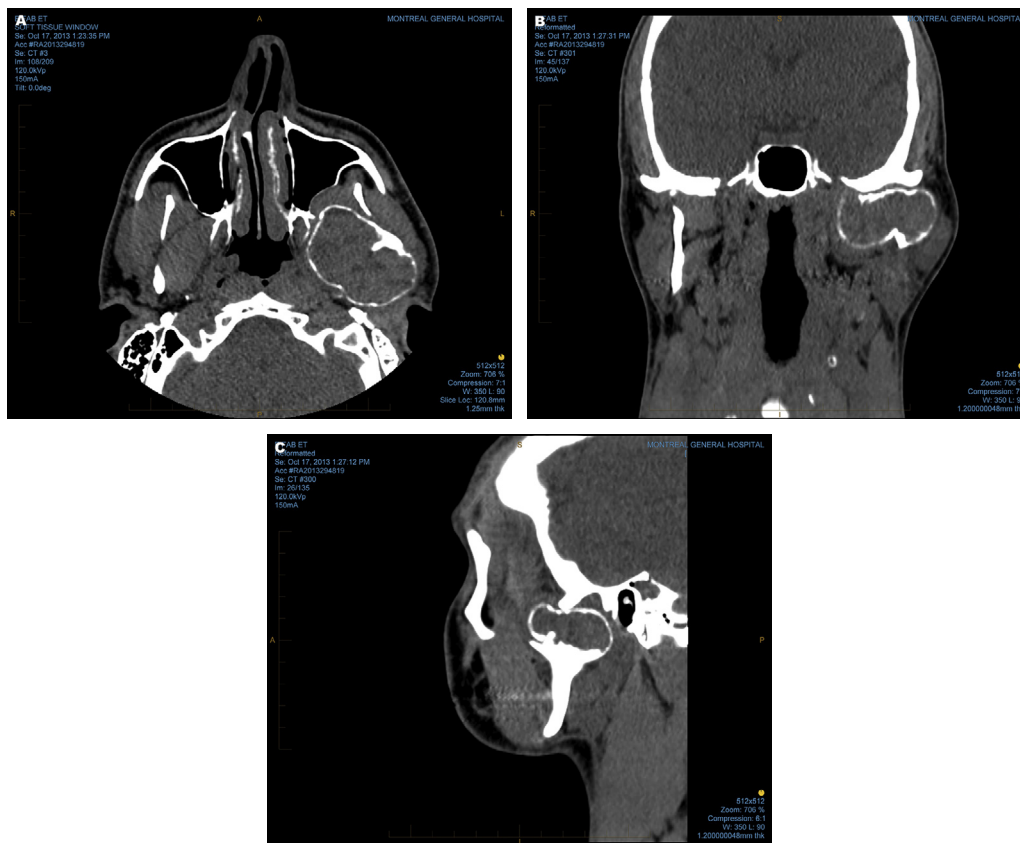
CT scan, soft tissue window, demonstrating a 5.5 × 3.8 × 3.4-cm radiolucent mass of the left mandibular condyle in the (A) axial (B) coronal, and (C) sagittal planes.
